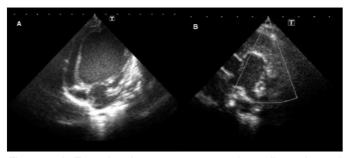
A. Four chambers are seen on echocardiography and the left ventricle is observed to be markedly enlarged. B. On parasternal short axis view on echocardiography, it is observed that the left coronary artery is originating from the pulmonary artery.
